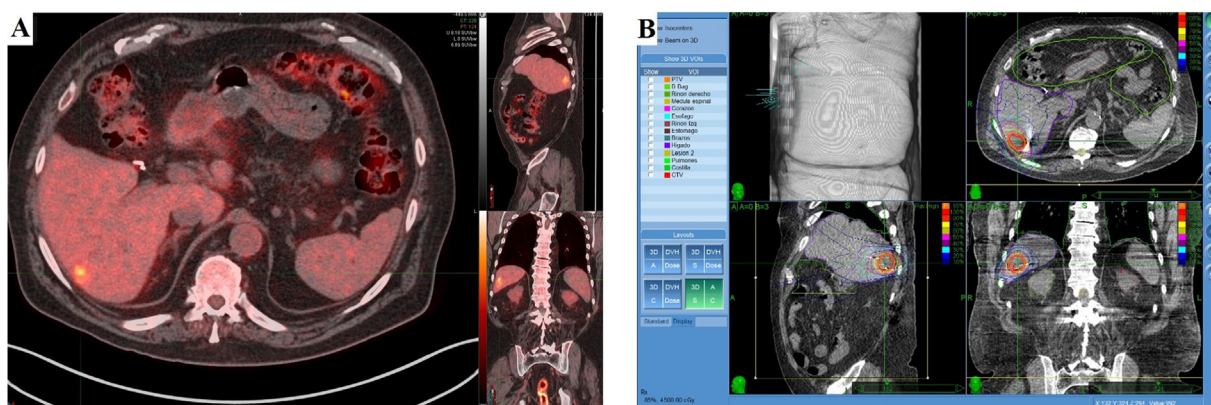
Diagnostic PET/CT showing one hepatic lesion used for treatment planning (A). Treatment planning images with a non-isocentric and non-coplanar radiation delivery system. Prescribed dose of 45 Gy in three fractions (B).
